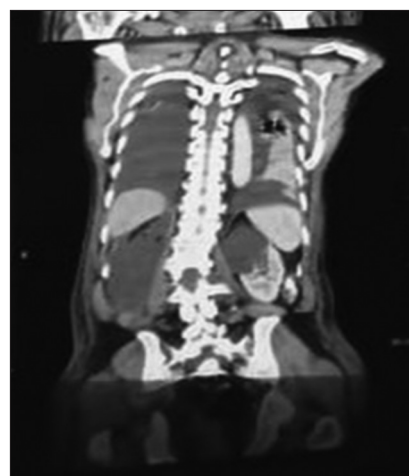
Computed tomography abdomen section showing transdiaphragmatic rent
